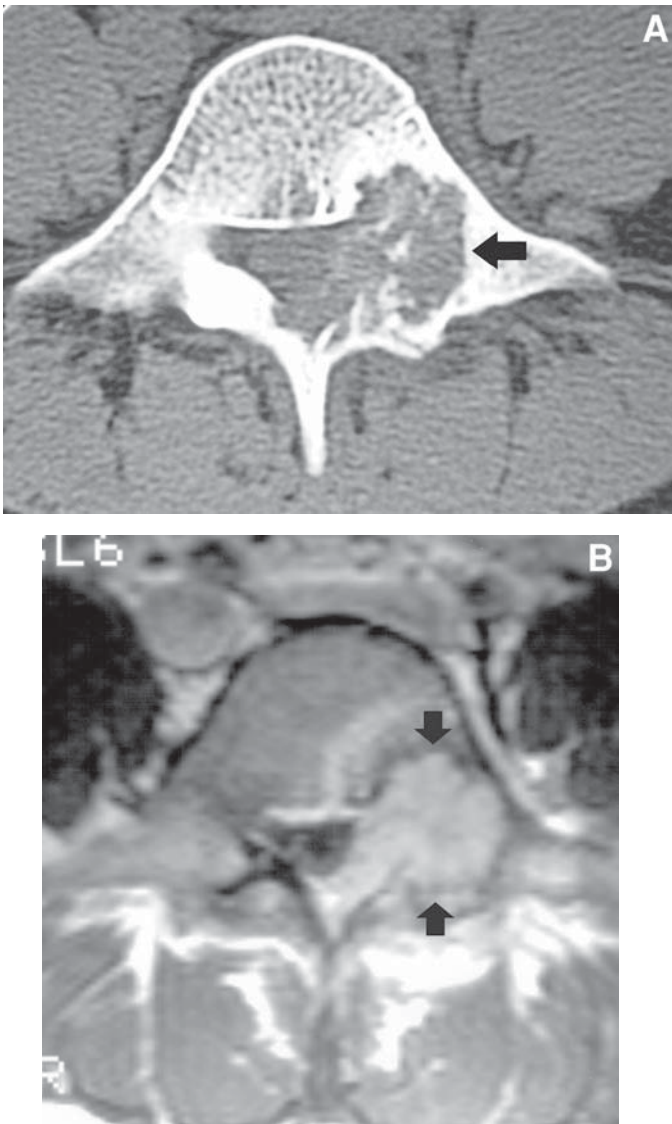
Osteoblastoma. Axial CT scan image (A) shows an expansile lytic lesion involving the posterior elements and posterior aspect of a lumbar vertebral body. Axial T2-weighted image (B) demonstrates increased signal in this lesion with some areas of low signal and surrounding reactive edema.
